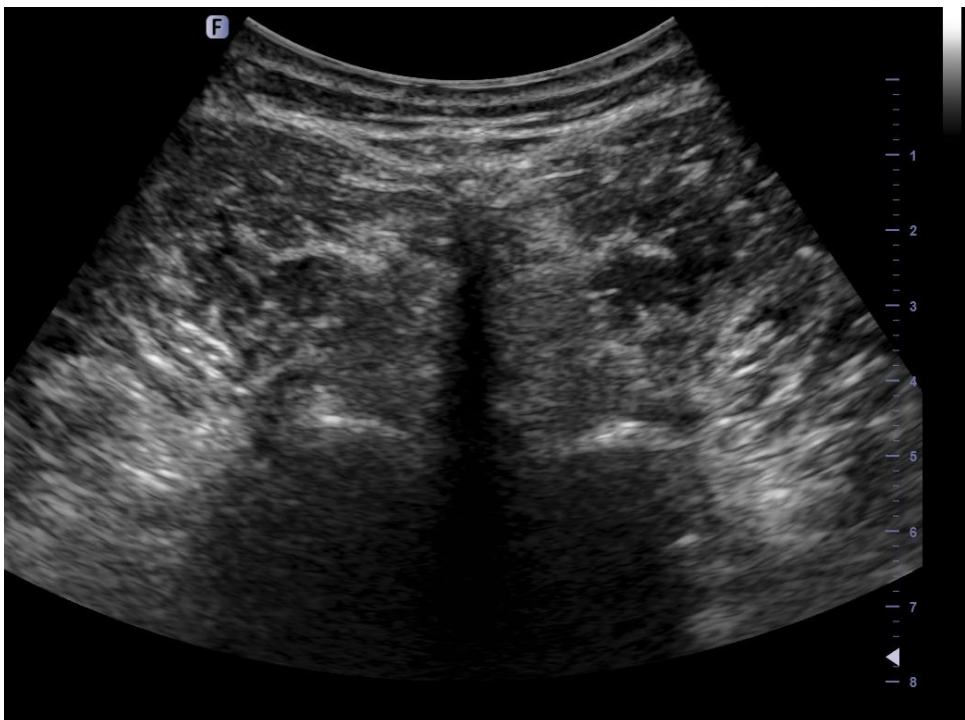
Ultrasound image of the multifidus muscle
